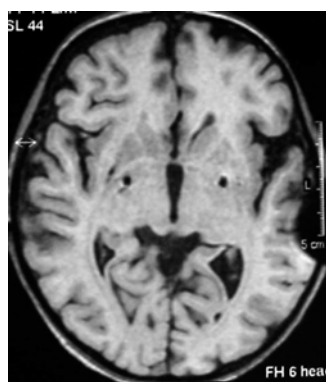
Postoperative MRI merged with the preoperative MRI planning showing electrode position (T1 weighted images)
